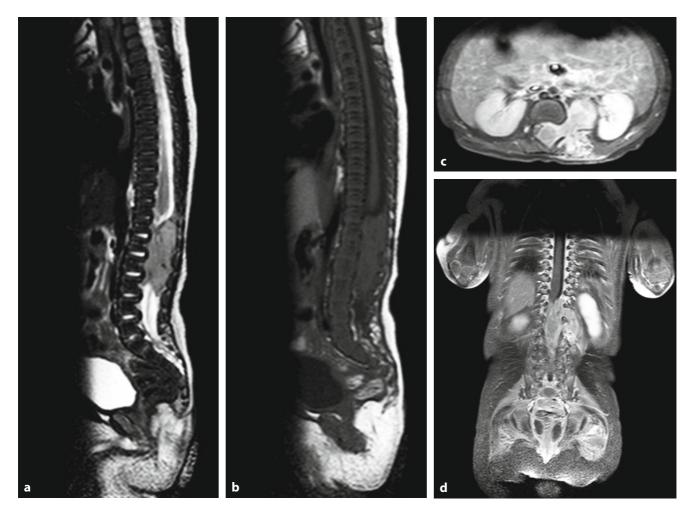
Paravertebral left neuroblastoma with paraspinal and intrarachideal infiltration through conjugation foramina. MR imaging T2 W (a) and T1 W pre (b) and after (c, d) gadolinium. (Courtesy Dr. Cecilia Parazzini)
